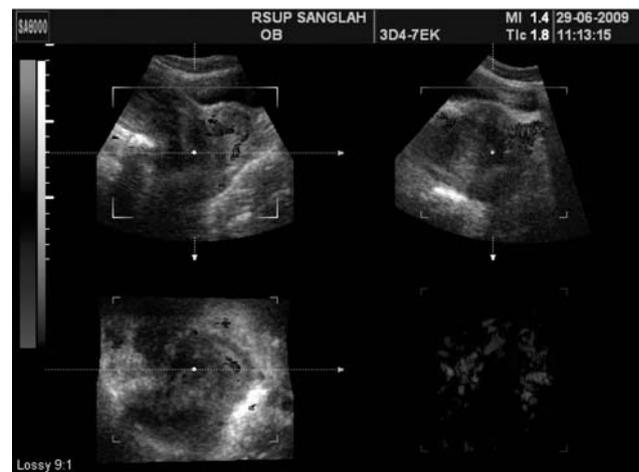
It can be seen from the figure above that after the tumoral mass was identified with transabdominal transducer, evaluation was conducted using the Doppler in order to identify the intratumoral blood vessels before the characteristics of the Doppler, S/D ratio, PI and RI were measured.
